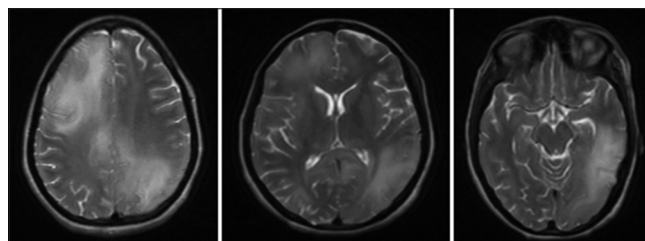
Magnetic resonance imaging brain T2 showing increase in lesion size and extent with widespread edema, increase in hyperintensities in the right frontal, left temporoparietal, and bilateral occipital lobes, distal body and selenium of the corpus callosum as compare to Figure 1
